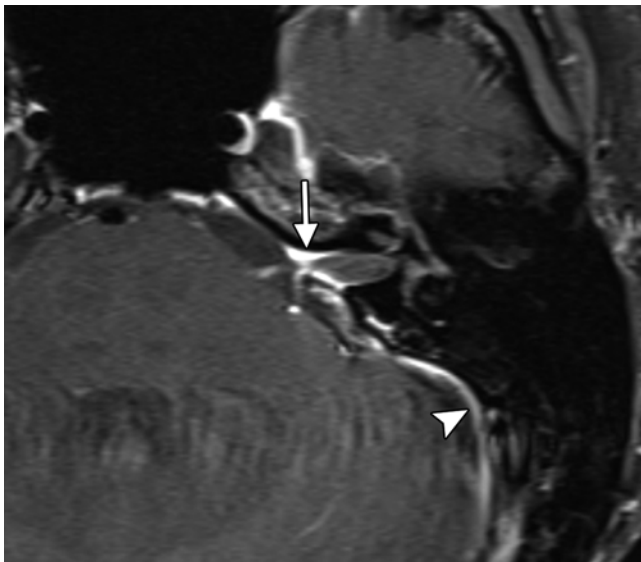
Linear enhancement. Axial postcontrast fat-suppressed T1-weighted MRI study showing linear dural enhancement within the left internal auditory canal (arrow) and in the posterior fossa (arrowhead).
